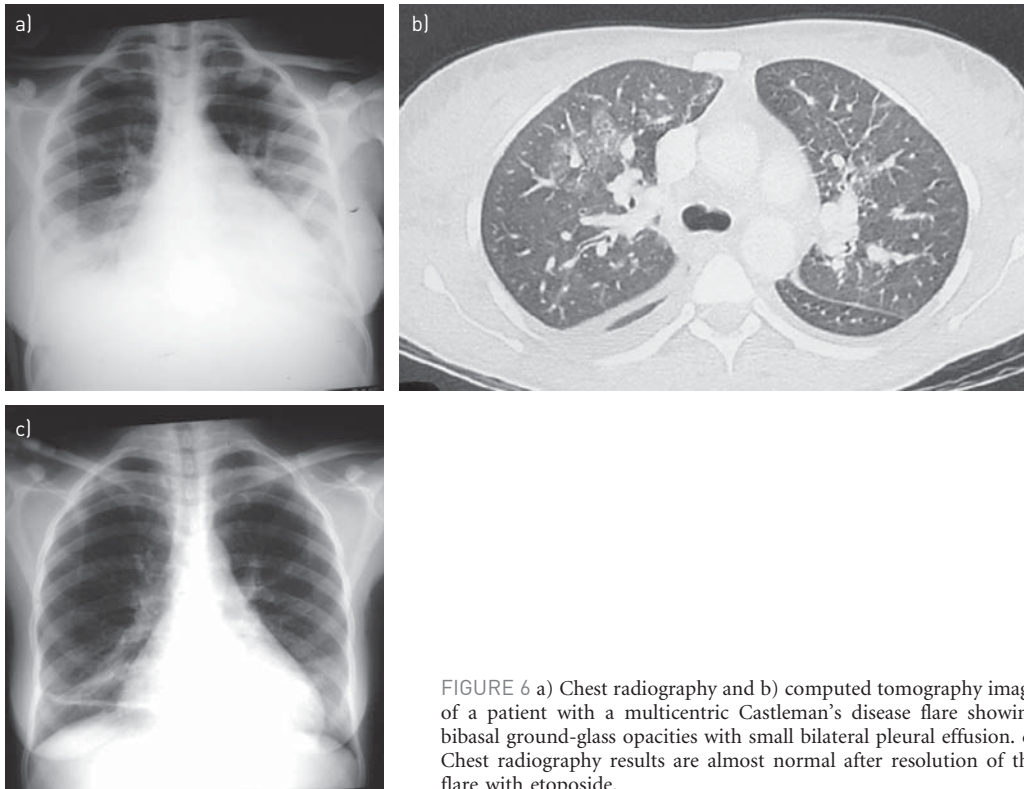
a) Chest radiography and b) computed tomography image of a patient with a multicentric Castleman's disease flare showing bibasal ground-glass opacities with small bilateral pleural effusion. c) Chest radiography results are almost normal after resolution of the flare with etoposide.
